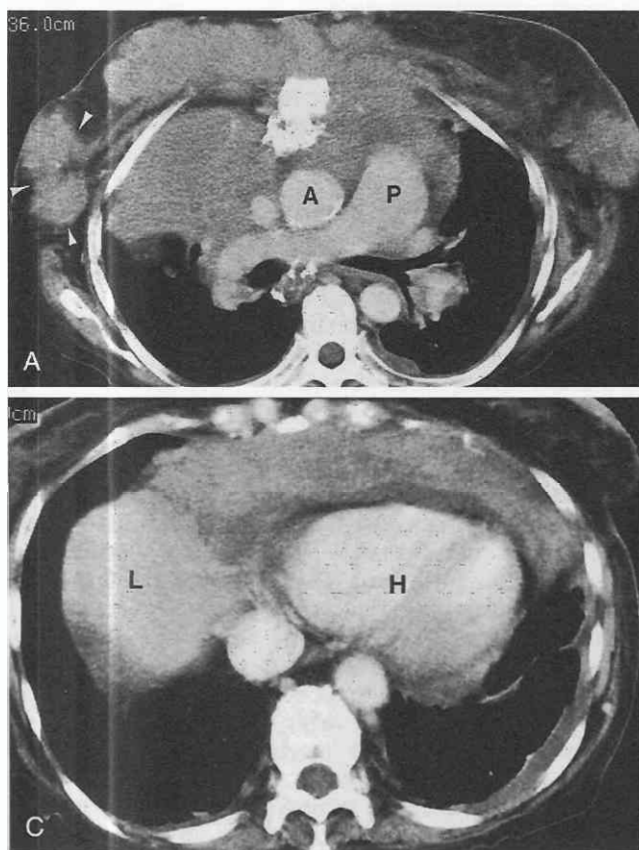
Non-Hodgkin's lymphoma manifesting as mediastinal mass with chest wall involvement. A-C, Contrast-enhanced CT shows a diffuse anterior mediastinal mass with chest wall invasion. The axillary nodes (arrowheads in A) are enlarged. The mass extends into neck and surrounds vessels (arrow in B). More caudally, the mass manifests as a mantle of soft tissue encasing heart (C). A, ascending aorta; H, heart; L, liver; P, main pulmonary artery; S, superior vena cava; T, trachea.
